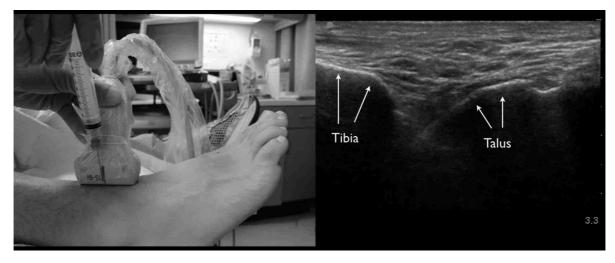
Ultrasound guided ankle aspiration using the out of plane technique.
